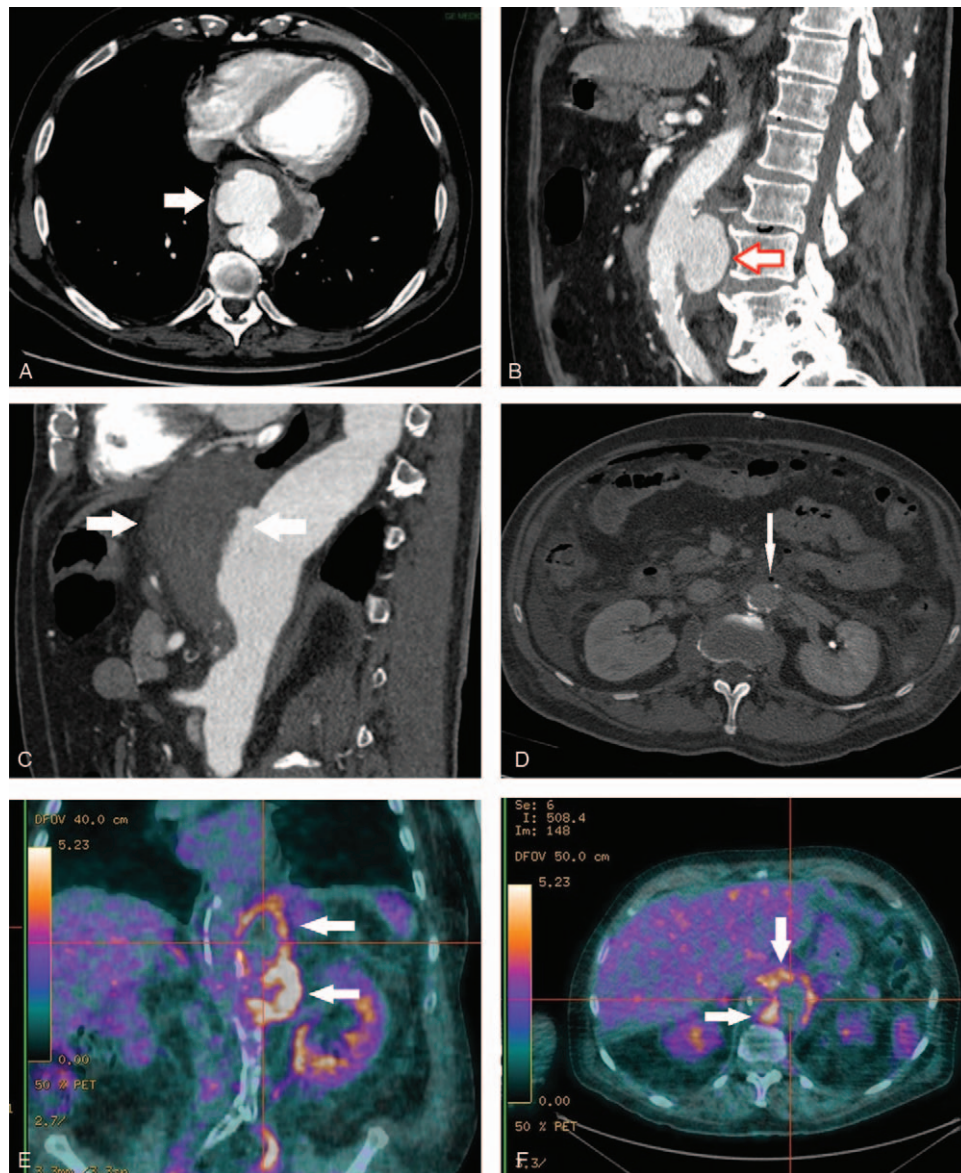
Imaging findings of infectious aortitis. (A) CT axial cut-section of descending thoracic aorta showing false anterior sacciform aneurysm. (B) CT sagittal reconstruction of abdominal aorta showing false posterior sacciform aneurysm. (C) CT sagittal reconstruction of thoracoabdominal aorta showing anterior contained rupture (hematoma). (D) CT axial cut-section of abdominal aorta showing wall pneumatosis (gaz bubble in the anterior segment). (E and F) PET-CT coronal and axial reconstruction showing intense hypermetabolism of the aortic wall. CT = computed tomography, PET-CT = positron emission tomography-computed tomography.
